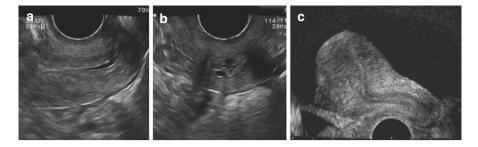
Normal appearance of cervix by transvaginal ultrasound, sagittal axis (a) and axial axis (b), transrectal ultrasound of the uterus and cervix (c)
